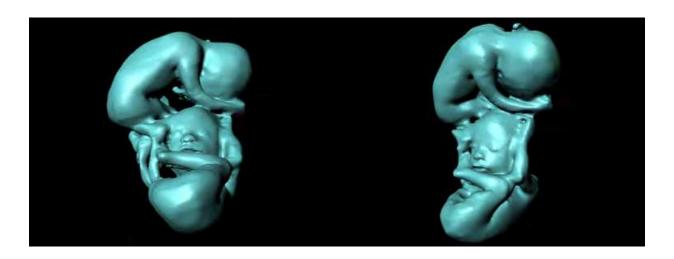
Virtual 3D model of 28 weeks twins from MRI scan allied to Ultrasonography 3D.
